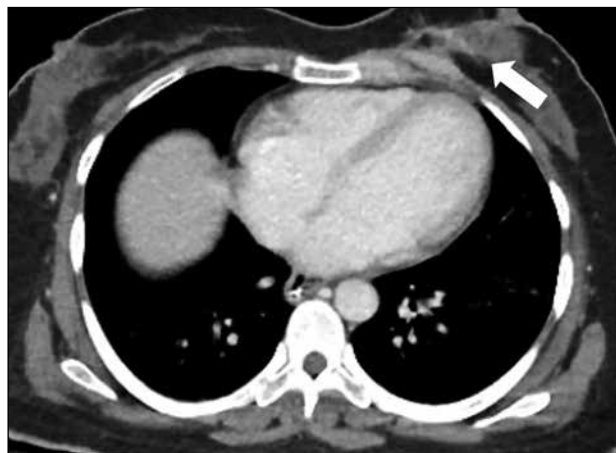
Computed tomography showing the incidental finding of an irregular enhancing left breast mass with spiculated margin and invasion of the underlying pectoralis major muscle (arrow).
